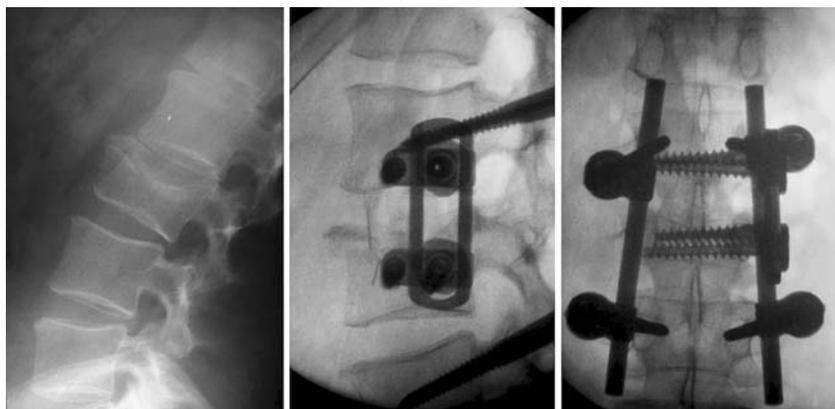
Stabilization of a L1 fracture (X-ray, lateral view) by endoscopic monosegmental spinal fusion L1 with an autogenous graft (iliac crest) and an additional instrumentation. The reduction was performed by an external fixator, which in combined posteroanterior surgery is removed at the end of the operation.
